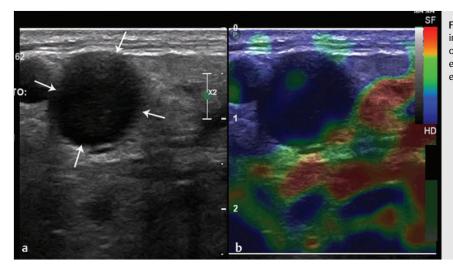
Split-screen (a) B-mode ultrasound image and (b) corresponding strain elastogram of a metastatic lymph node (*arrows*). The elastogram shows the node appearing almost entirely blue, that is, hard (pattern 5).
